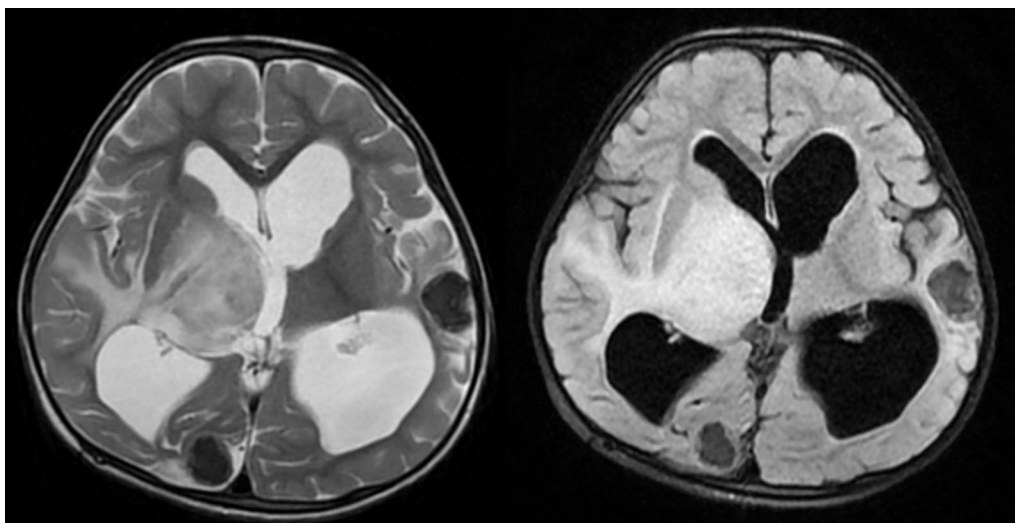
MRI T2 and FLAIR sequences showing multiple tuberculomas with hydrocephalus
